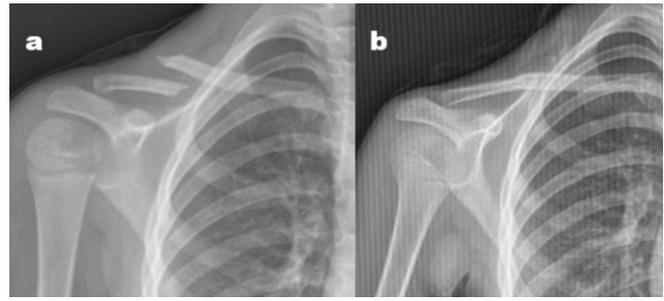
Radiographic appearance demonstrating complete remodeling of a pediatric midshaft clavicle fracture approximately 18 months after injury. (a) AP radiograph of a 7-year-old male patient showing a displaced diaphyseal fracture. (b) AP radiograph of the same patient demonstrating a fully remodeled clavicle.
